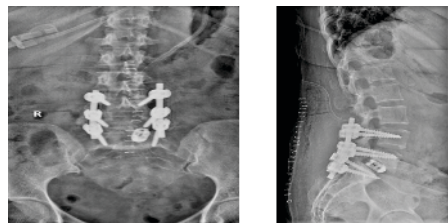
Post-operative X-ray of LS Spine: AP and Lateral view
